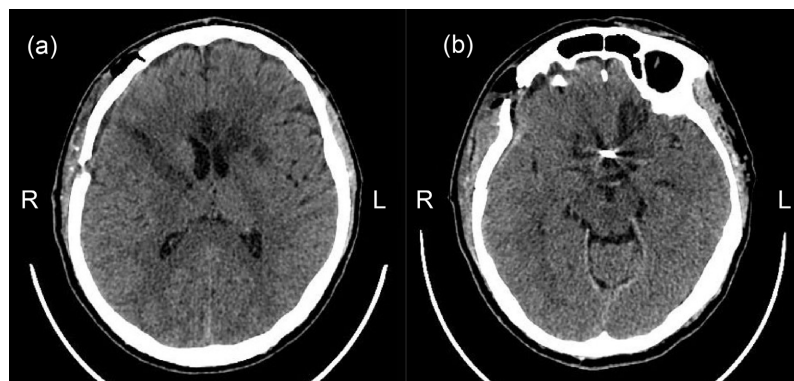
(a)-(b): Plain brain CT showing hyperdense areas suggestive of communicating artery aneurysm, with no early signs of bleeding or active hydrocephalus.
